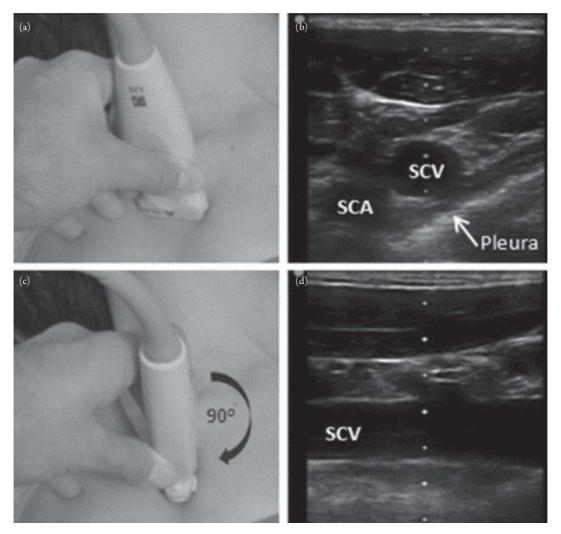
(a) The linear transducer is placed perpendicularly and inferior to clavicle. (b) Identified anatomical structures include the transverse (short axis) view of subclavian vein (SCV), subclavian artery (SCA) and pleura. (c) With SCV centrally positioned, the transducer is rotated 90° clockwise until (D) longitudinal view of subclavian vein is obtained. Adapted from Figure 2 of Rezayat T, Stowell JR, Kendall JL, et al. Ultrasound-guided cannulation: time to bring subclavian central lines back. West J Emerg Med. 2016;17(2):216–221.
